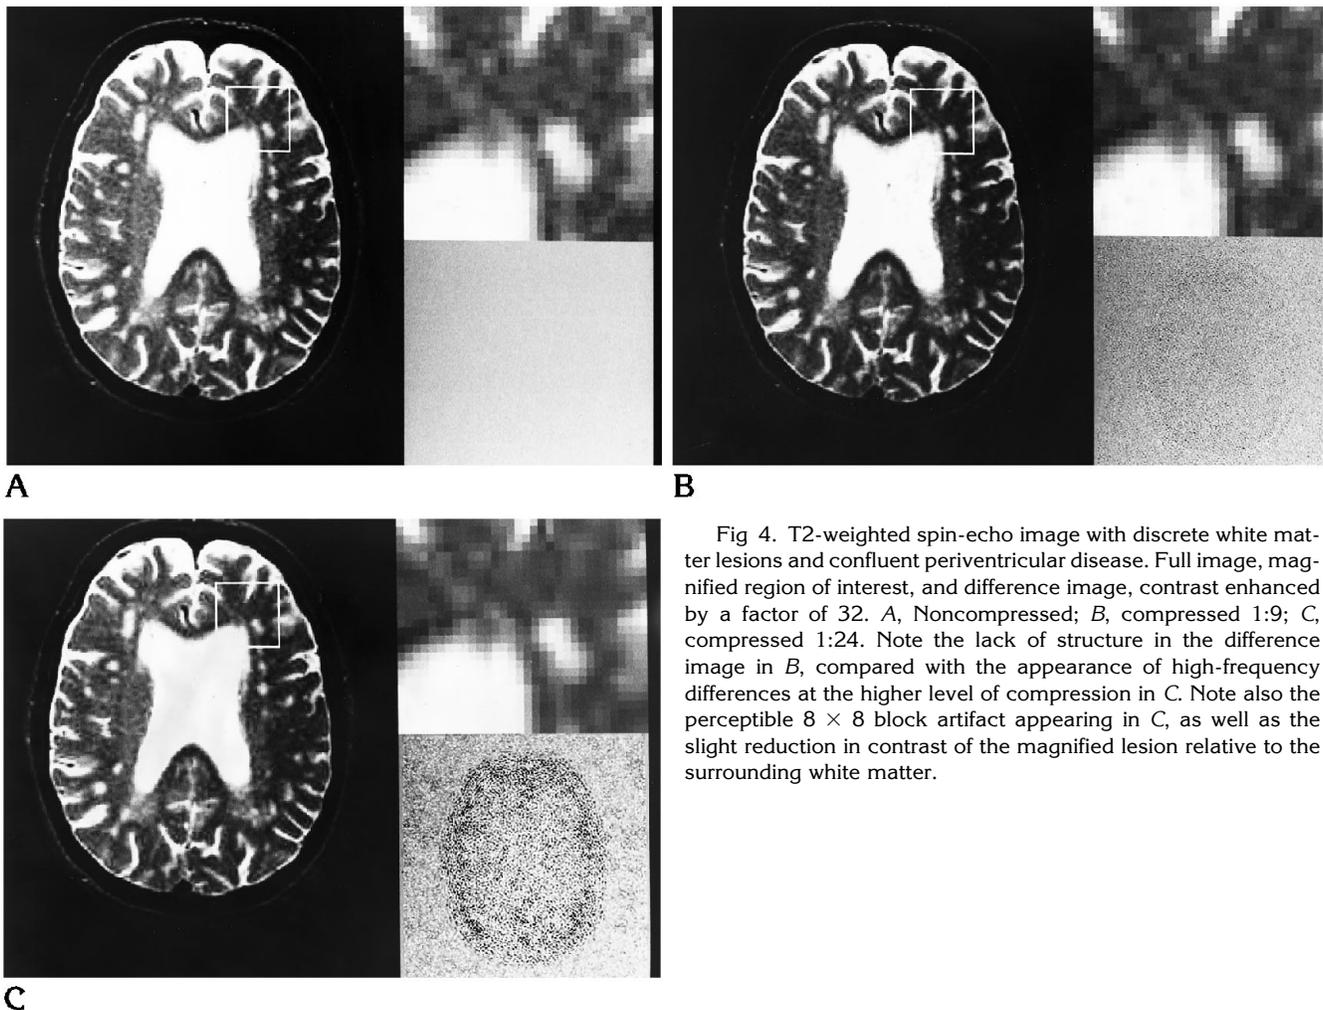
T2-weighted spin-echo image with discrete white matter lesions and confluent periventricular disease. Full image, magnified region of interest, and difference image, contrast enhanced by a factor of 32. *A*, Noncompressed; *B*, compressed 1:9; *C*, compressed 1:24. Note the lack of structure in the difference image in *B*, compared with the appearance of high-frequency differences at the higher level of compression in *C*. Note also the perceptible 8×8 block artifact appearing in *C*, as well as the slight reduction in contrast of the magnified lesion relative to the surrounding white matter.
